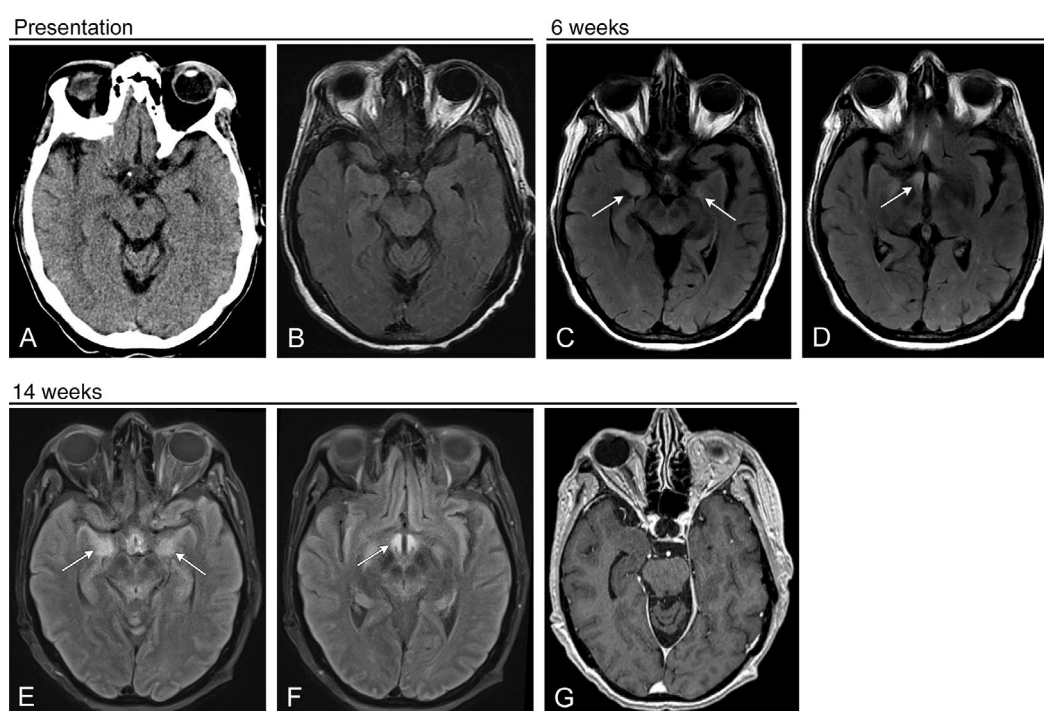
Herpes simplex virus 6 (HHV-6) encephalitis. A 58-year-old female with history of bone marrow transplant presents with recurrent episodes of altered mental status. Initial CT (A) and MRI (B; FLAIR) show no abnormality. Follow-up MRI performed 6 weeks later shows FLAIR hyperintensity in the hippocampi (C) and hypothalamus (D). There was no corresponding restricted diffusion or enhancement (not shown). Follow-up MRI performed 8 weeks later shows increasing FLAIR hyperintensity in the hippocampi (E) and hypothalamus (F). Parenchymal volume is preserved. Postcontrast T1-weighted image shows no abnormal enhancement (G). At this time, cerebrospinal fluid sample was obtained and was positive for HHV-6.
